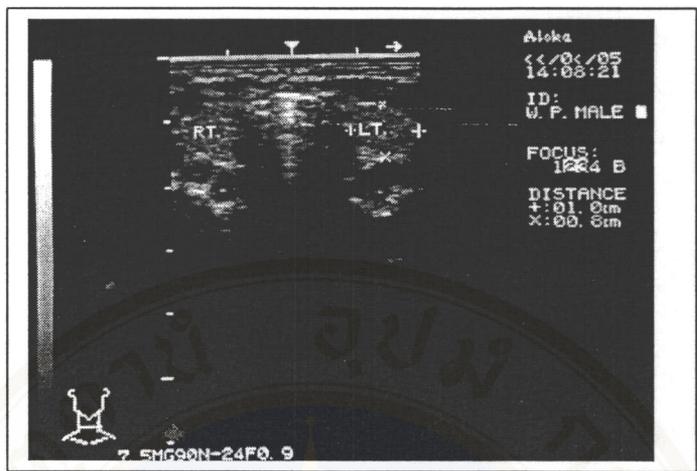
Ultrasonography : transversal section of left and right thyroid ultrasonography.
